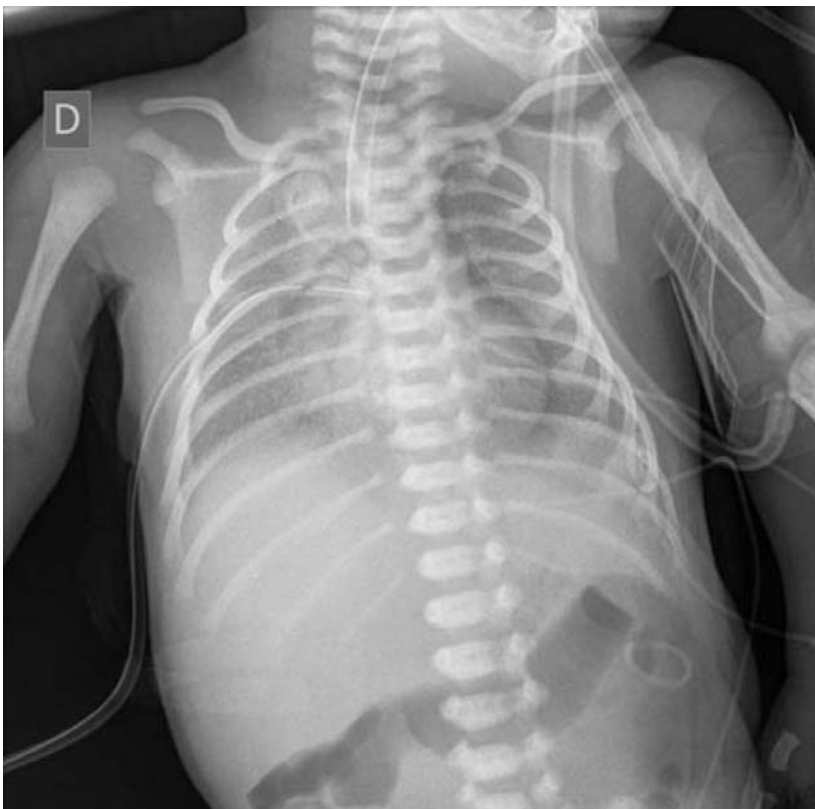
A chest x-ray with evident signs of hyaline membrane disease and pneumothorax on the right and left sides of the chest.
